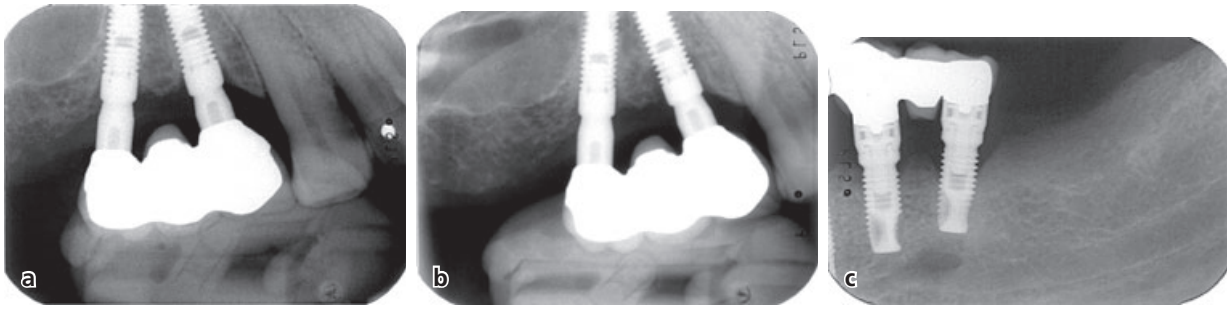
In radiograph (b), the mesial implant has marginal bone loss that was not evident a year before. In radiograph (c), the most distal implant has marginal bone loss involving about a third of the implant length.
